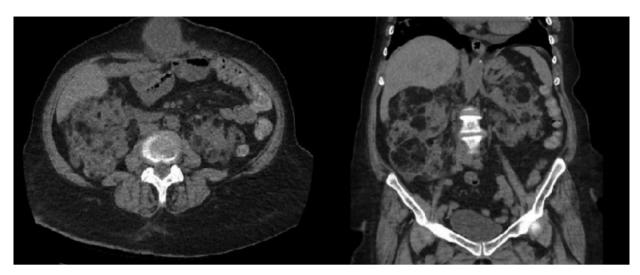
Control CT image at one year after the procedure CT: Computed tomography
